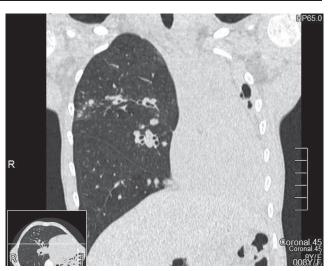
Pulmonary CT – Left lung fibroelectasis, decreased left hemithorax, mediastinal moving to the left. 8-year-old child, with CF, chronic pulmonary infection with 2 multidrogresistent strains of Ps. aeruginosa, CFTR genotype delF508/X
